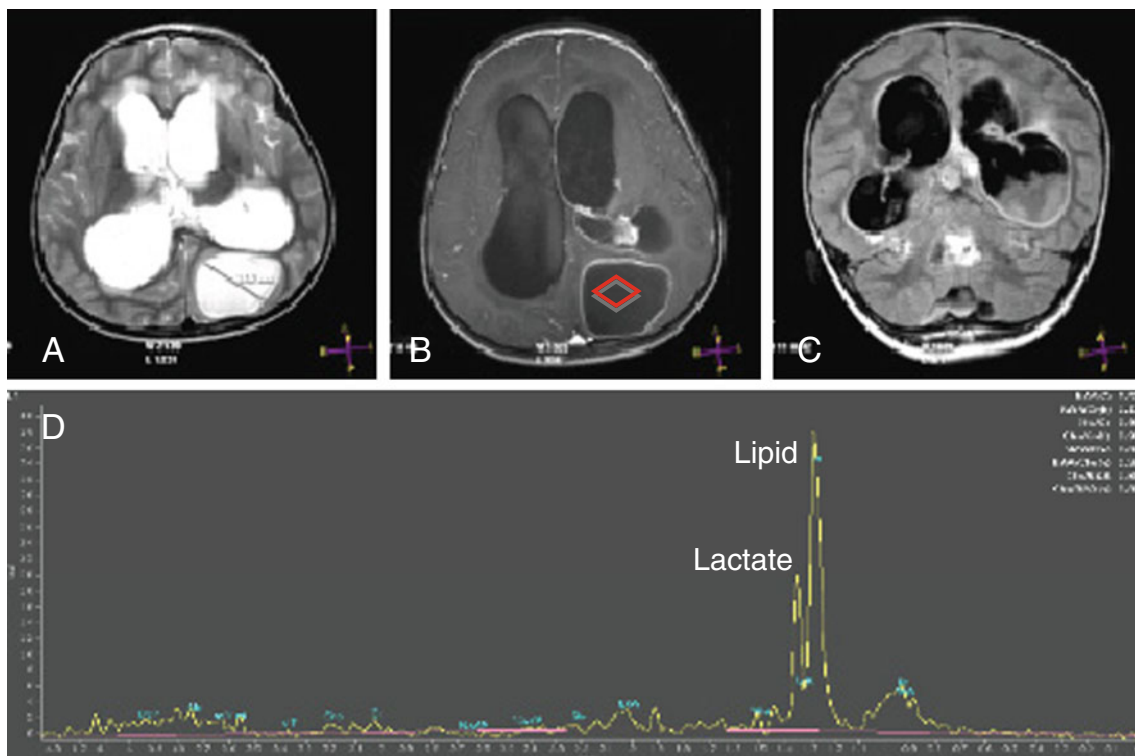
Brain MRI of a 4-year-old boy (case 2) and in vivo ^1H -MRS of pus from cerebral abscess. Axial T2-weighted (a), contrast-enhanced T1-weighted (b), and coronal FLAIR (c) MR images reveal a large left occipital abscess dorsal to the inflamed lateral ventricle. The ependyma of the ventricle shows a significant contrast enhancement;
